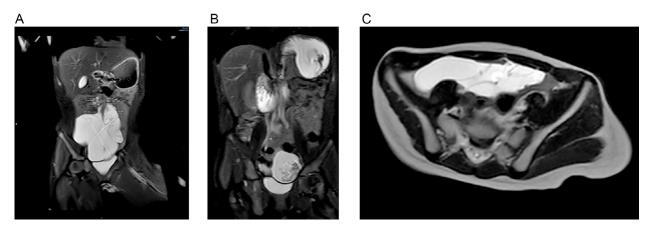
(A-C) Acute Abdominal MRI without Contrast. The patient could not cooperate in executing the entire investigation—Coronal 2B - SPAIR sequence, and Coronal (A) and Axial (C) T2-weighted images showed the presence of a large fluid-filled lesion with internal septa with a possibility of hemorrhage/calcification and no signals in the diffusion restriction sequences. The lesion extended from the epigastrium to the lower abdomen measuring 9 cm X 11 cm. Fluid retention and dilatation of the stomach and the 1. st and 2nd parts of the duodenum with a probability of being followed by a whirl sign- raising the suspicion of internal herniation. Also, a possibility of the lesion being a benign cystic tumor.
